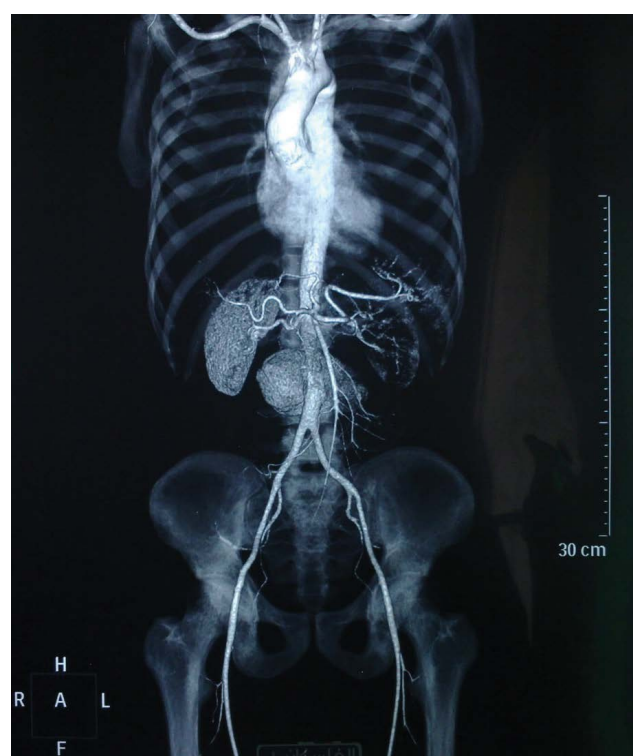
CTA showing infrarenal abdominal aortic aneurysm.
